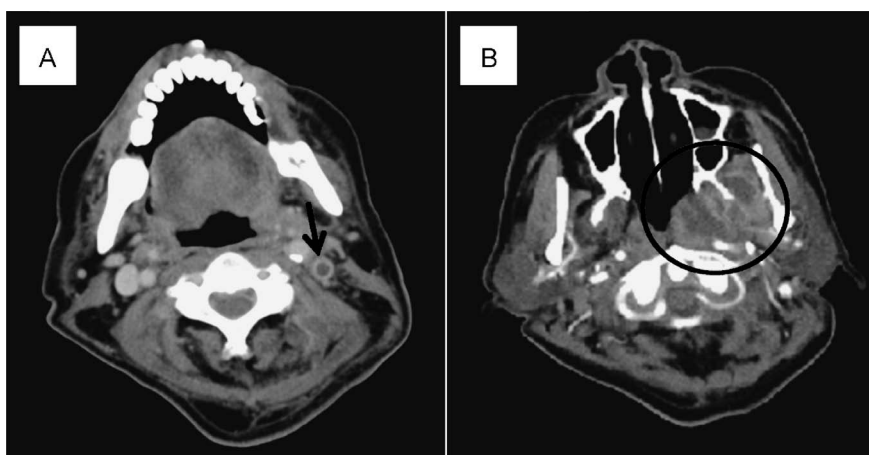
Enhanced computed tomography image of the neck on Day 9. (A) The filling defects in the left internal jugular vein. (B) The low-density area in the left side of the pharynx and pterygoid muscle.
